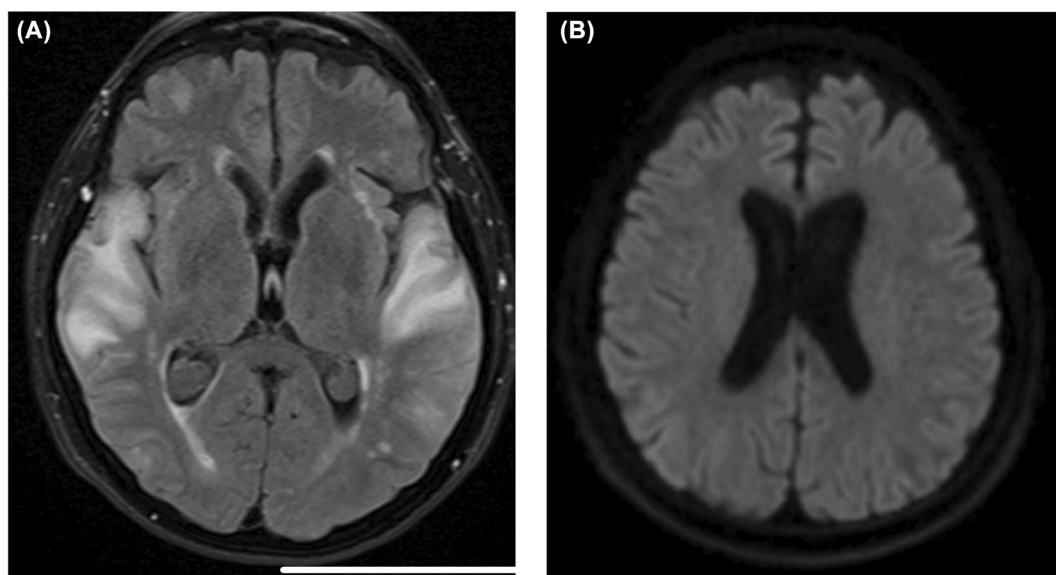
(A) ARIA MRI FLAIR axial (B) ARIA MRI DWI axial.
